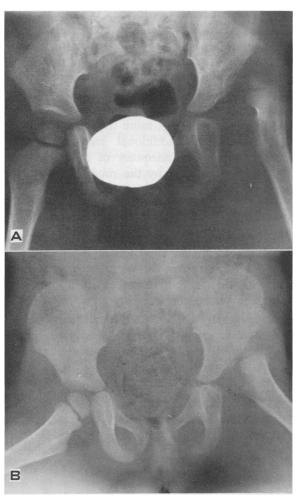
Typical superior displacement of the left hip, as seen in the anteroposterior view (A, above) and the frog-leg lateral view (B, below). Note the failure of acetabular development and the relative hypoplasia of the entire femoral head and neck on the left. Note also that the left hip cannot be abducted as well as the right hip, because of tightness of the adductor muscles. This is a roentgenogram of a 3-year-old girl, untreated at the time. (Reproduced by permission from Specht EE: Am Fam Physician 9:88-96, Feb 74)
